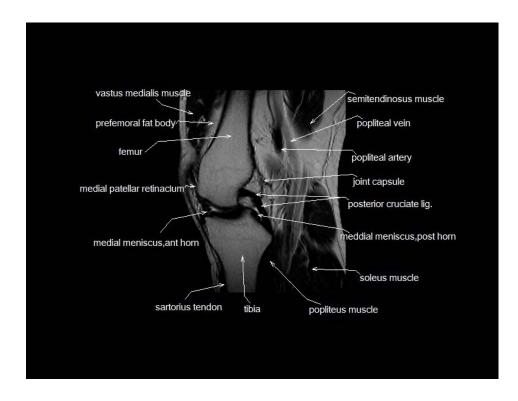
MRI imaging of the knee joint. Sagittal view (Sharma et al., 2014)
